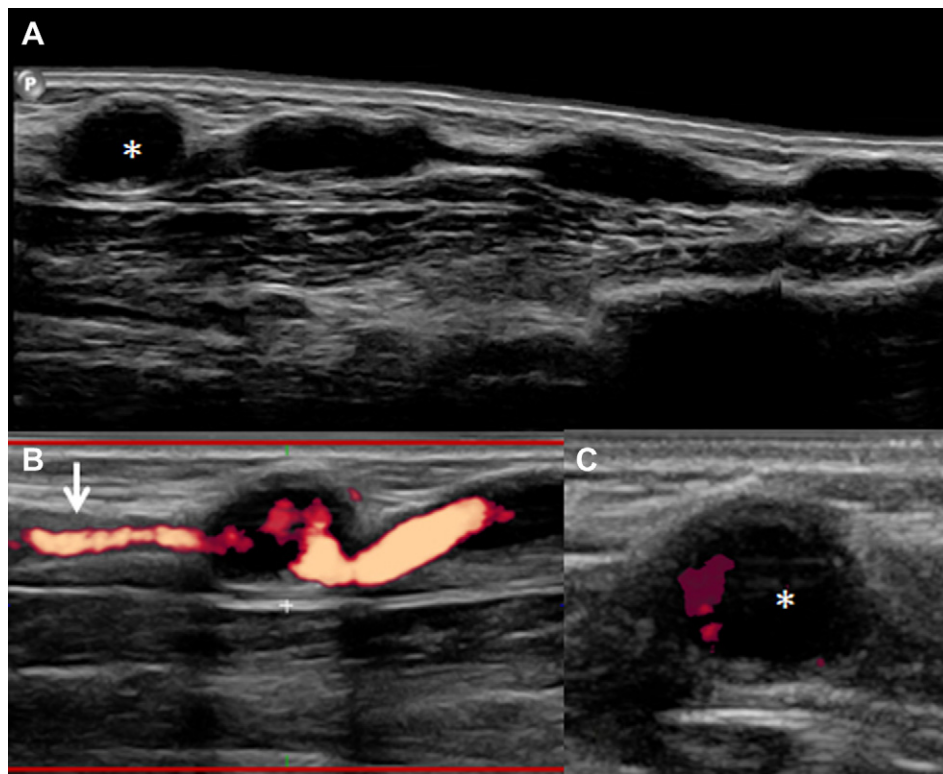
A 28-year-old woman with polyarteritis nodosa presented with pulsatile nodules on her left forearm. (A) Longitudinal scan of the left radial artery showing four aneurysms (*). Aneurysm formation resulted from the dilatation of diseased arterial wall. Power Doppler showing (B) the thickened arterial wall (arrow). (C) Transverse scan of the aneurysm (*) showing thrombus with partial occlusion. The thrombus was heterogeneously hypoechoic and lacked Doppler signals.
